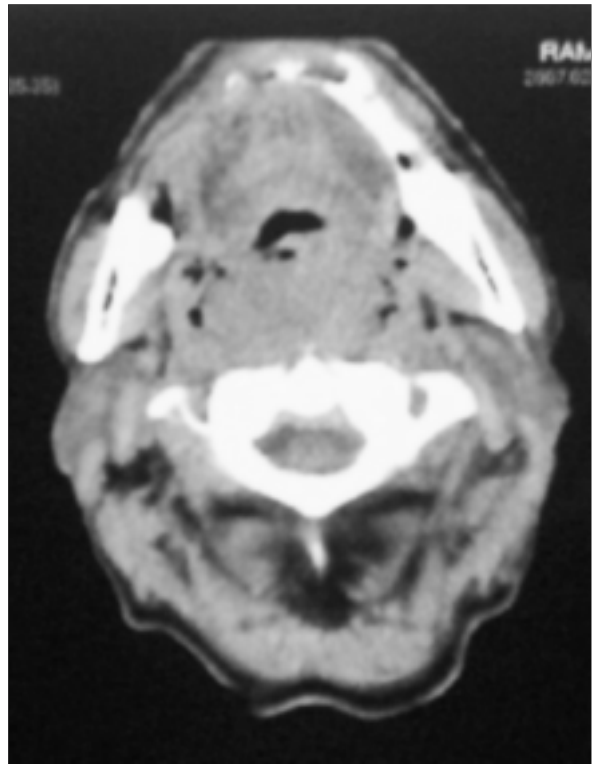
Nasopharynx CT scan revealing a 65x35x50 mm mass obliterating the posterosuperior nasopharyngeal wall, retrostyloid and parapharyngeal spaces.
